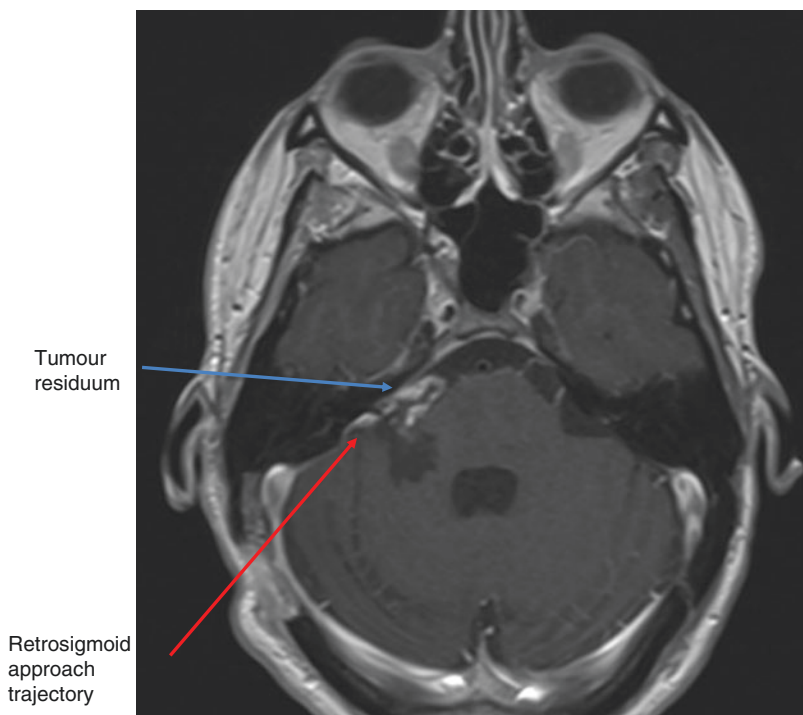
MRI Brain T2 weighted axial image of a large right-sided CPA tumour. In contrast to Fig. 13.14, the bulk of the tumour runs along the petrous bone. This tumour could be excised by a retrosigmoid approach with acceptable cerebellar retraction. Access to the anterior part of the tumour may be complicated by the position of the facial nerve, but this will not be improved by a translabyrinthine approach
